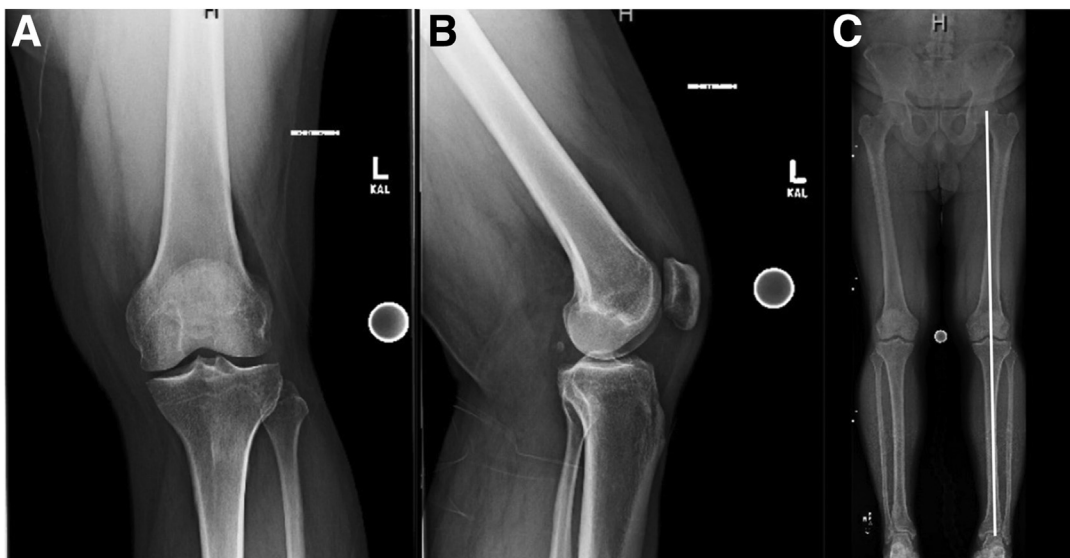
(A and B) Anteroposterior and lateral radiographs of the left knee. (C) Extremity alignment radiographs evaluating the alignment of the bilateral lower extremities demonstrating neutral mechanical alignment of the left lower extremity.
